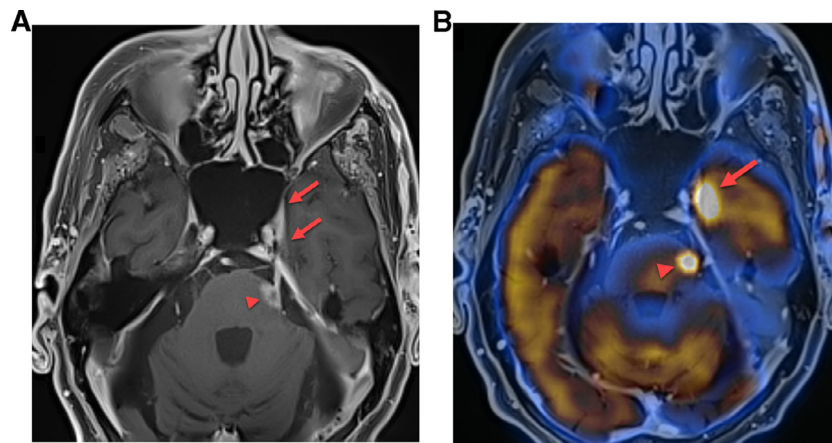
Perineural spread in PET/MR (contrast-enhanced T1-weighted fat-suppressed images). FDG-avid contrast-enhancing tumor extension is seen along the trigeminal nerve in the lateral wall of the cavernous sinus and in Meckel's cave (arrows on A and B), all the way to the thickened cisternal segment of the nerve and the root entry zone in the pons (arrowhead on A and B).
